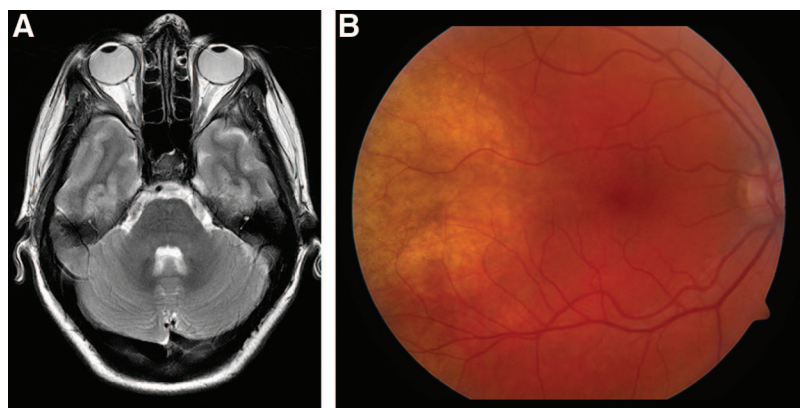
A, Magnetic resonance imaging (MRI) brain after three cycles of chemotherapy showing complete resolution of the choroid lesion. B, Ophthalmology images postchemotherapy showing complete resolution of the choroid lesion.
